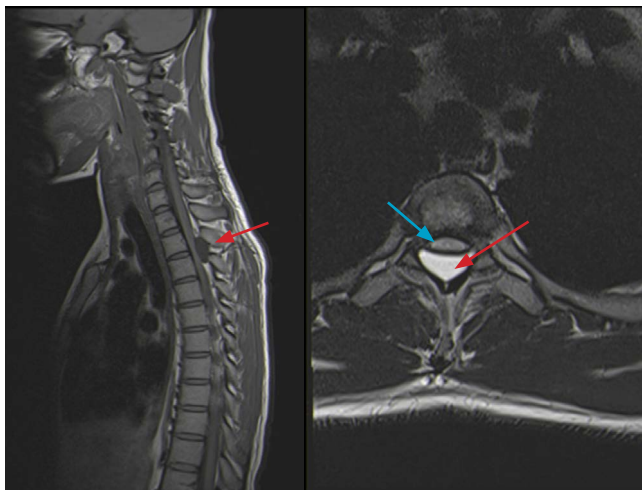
MRI T1 sagittal and T2 axial showing T2/T3 level spinal cyst in thoracic spine; red arrow – hydatid cyst, blue arrow – spinal cord compression
